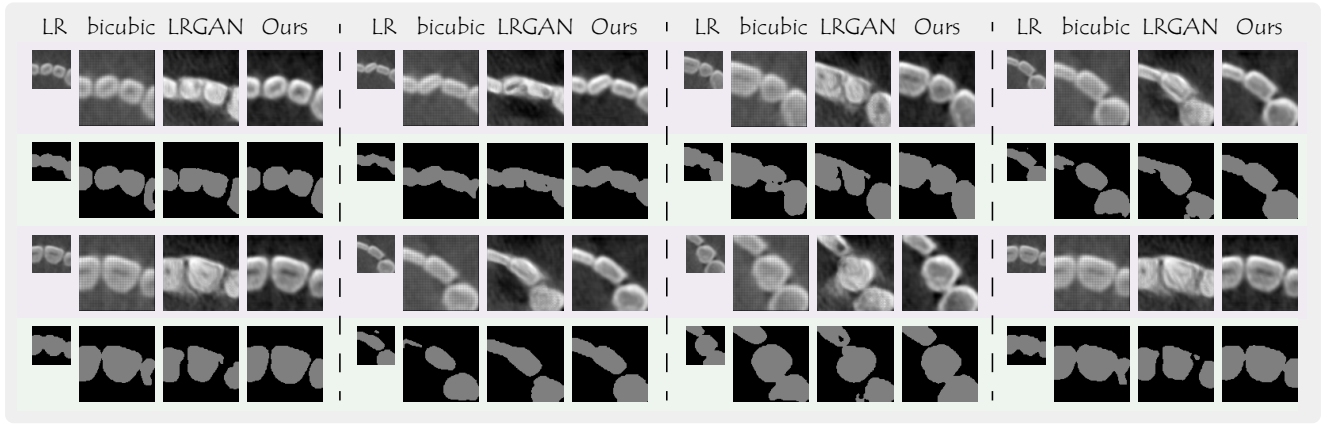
Comparison of semantic segmentation by UNet (Ronneberger et al. 2015) on high-resolution dental CBCT sub-images super-resolved by Bicubic Interpolation, LRGAN (Bulat et al. 2018) and our SCGAN on the low-resolution sub-images.
